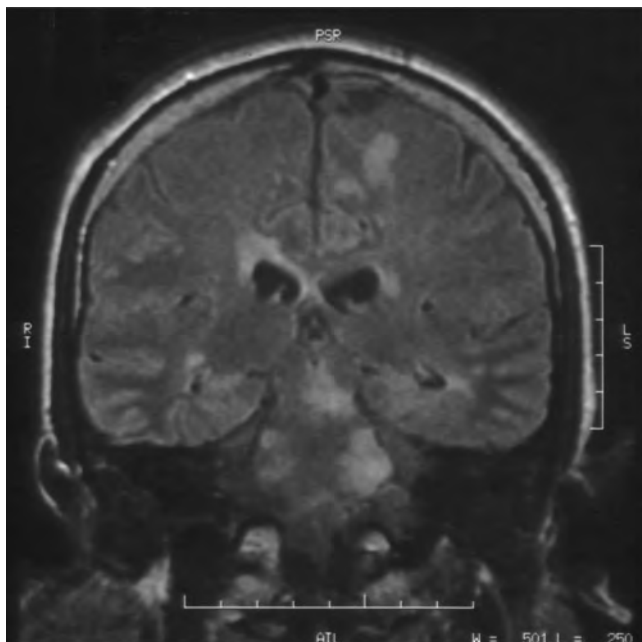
Extensive plaques of demyelination in a patient with progressive central apnoea requiring ventilatory support (MRI T1W).
